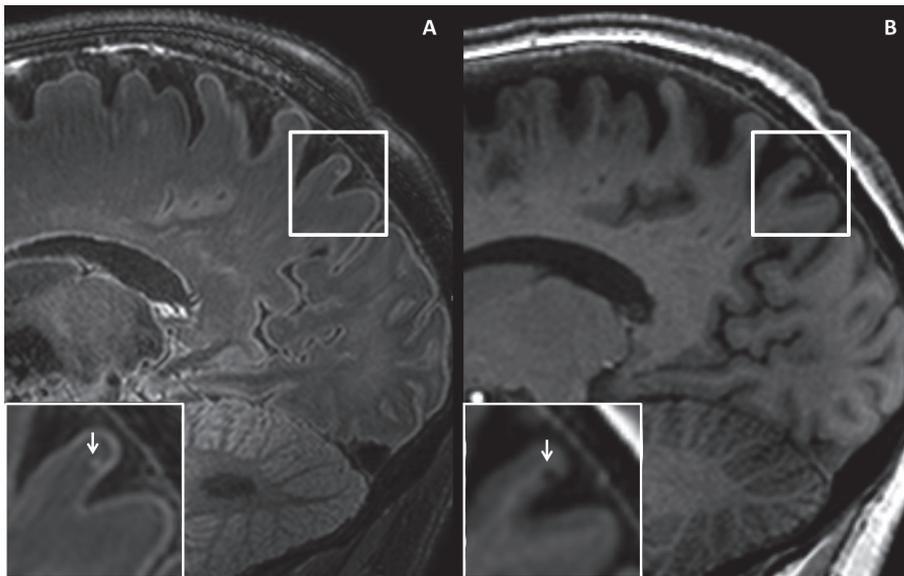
An example of a cortical microinfarct, which appears hyperintense on FLAIR (A) and hypointense on T1-weighted (B) 7 tesla MR images.
